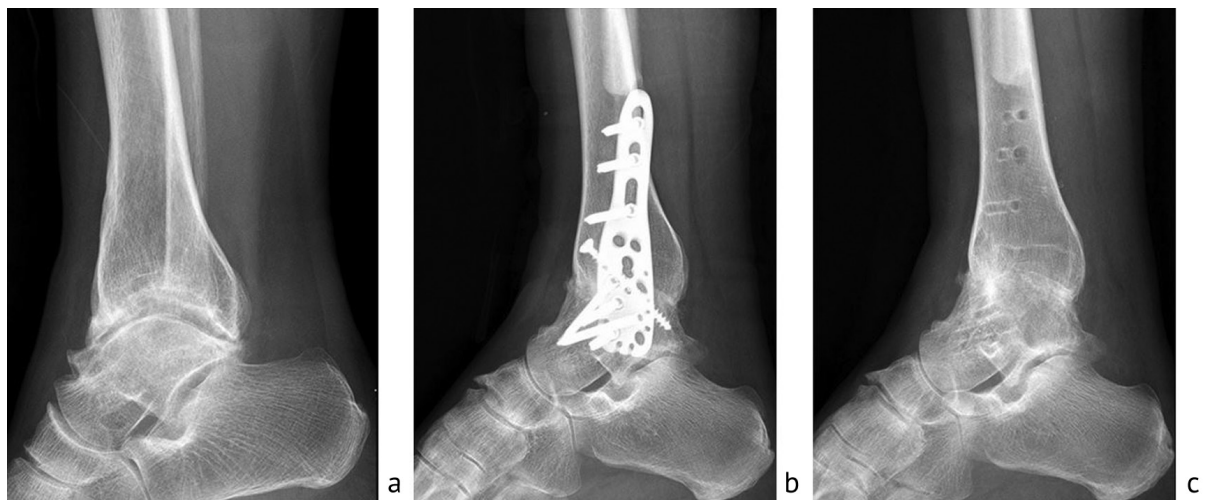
Lateral radiographs of the right ankle joint in a 45-year-old patient: dynamics of the arthrodesis process with bone plate fixation and screws: before surgery (a); 6th month after surgery (b); 12th month after surgery (c)
